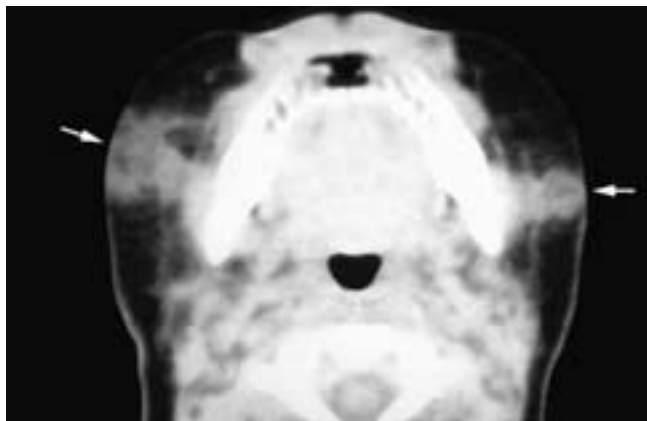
Axial CT scan shows a partially infiltrative-appearing subcutaneous soft-tissue mass (arrows) in each side of the face. This newborn had subcutaneous fat necrosis.
